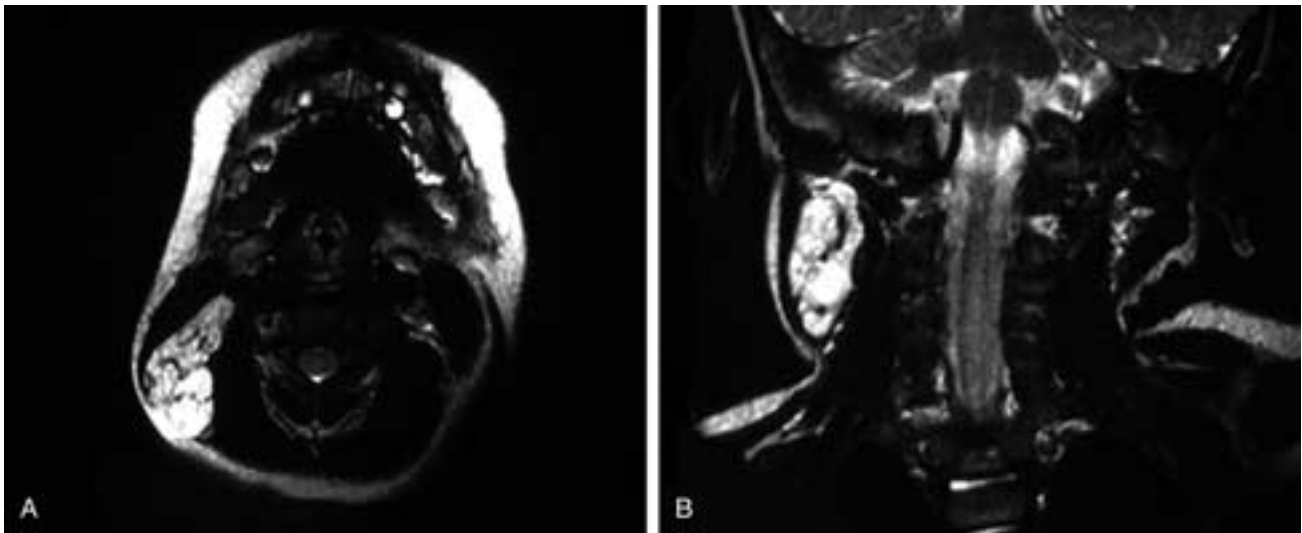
Axial (A) and coronal (B) T2-weighted MR images show a noninfiltrating mass with overall high signal intensity in the fat of the posterior right neck, deep to the sternocleidomastoid muscle. There are vascular flow voids within this arteriovenous vascular malformation.
